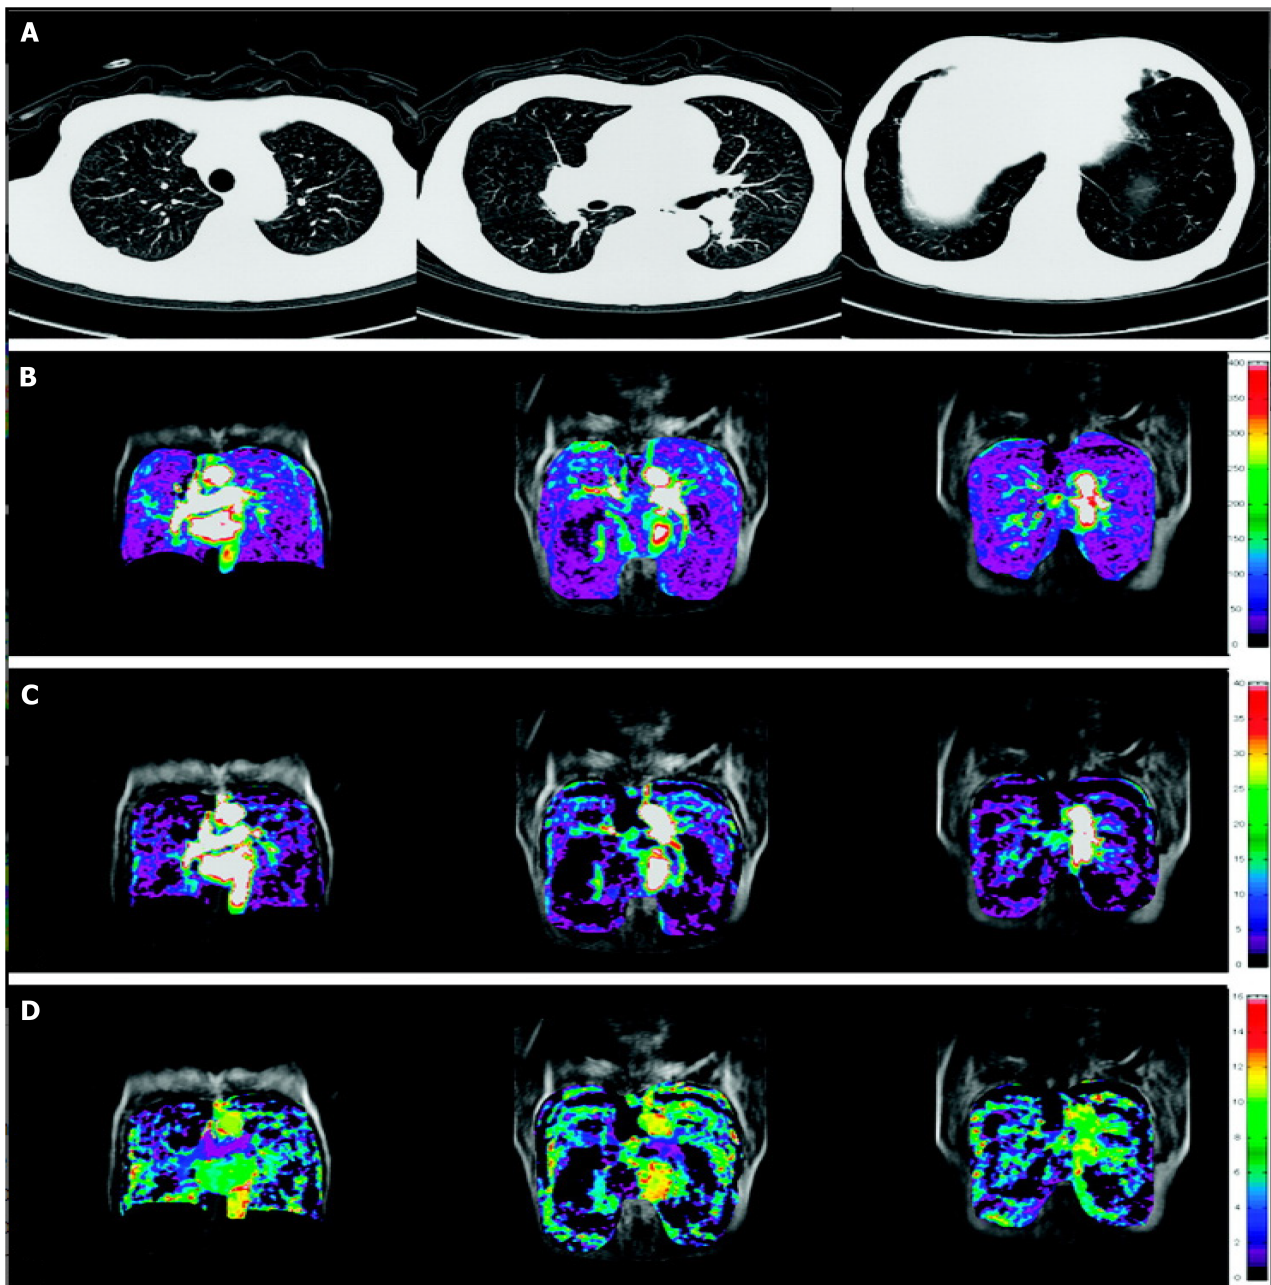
Comparing computed tomography chest and dynamic contrast enhanced perfusion magnetic resonance imaging for identifying perfusion defects in pulmonary hypertension patient with COPD. A: Chest computed tomography showing lobular emphysema in the lungs; B-D: Quantitative perfusion maps (anterior to posterior) showing heterogeneously reduced pulmonary blood flow, pulmonary blood volume and mean transit time respectively representing thromboembolic occlusion in respective pulmonary segments. Note on the right-hand side, quantitative scale from top to bottom showing higher to lower quantitative values. Citation: Ohno Y, Hatabu H, Murase K, Higashino T, Kawamitsu H, Watanabe H, Takenaka D, Fujii M, Sugimura K. Quantitative assessment of regional pulmonary perfusion in the entire lung using three-dimensional ultrafast dynamic contrast-enhanced magnetic resonance imaging: Preliminary experience in 40 subjects. *J Magn Reson Imaging* 2004; 20: 353-365 [PMID: 15332240 DOI: 10.1002/jmri.20137].
